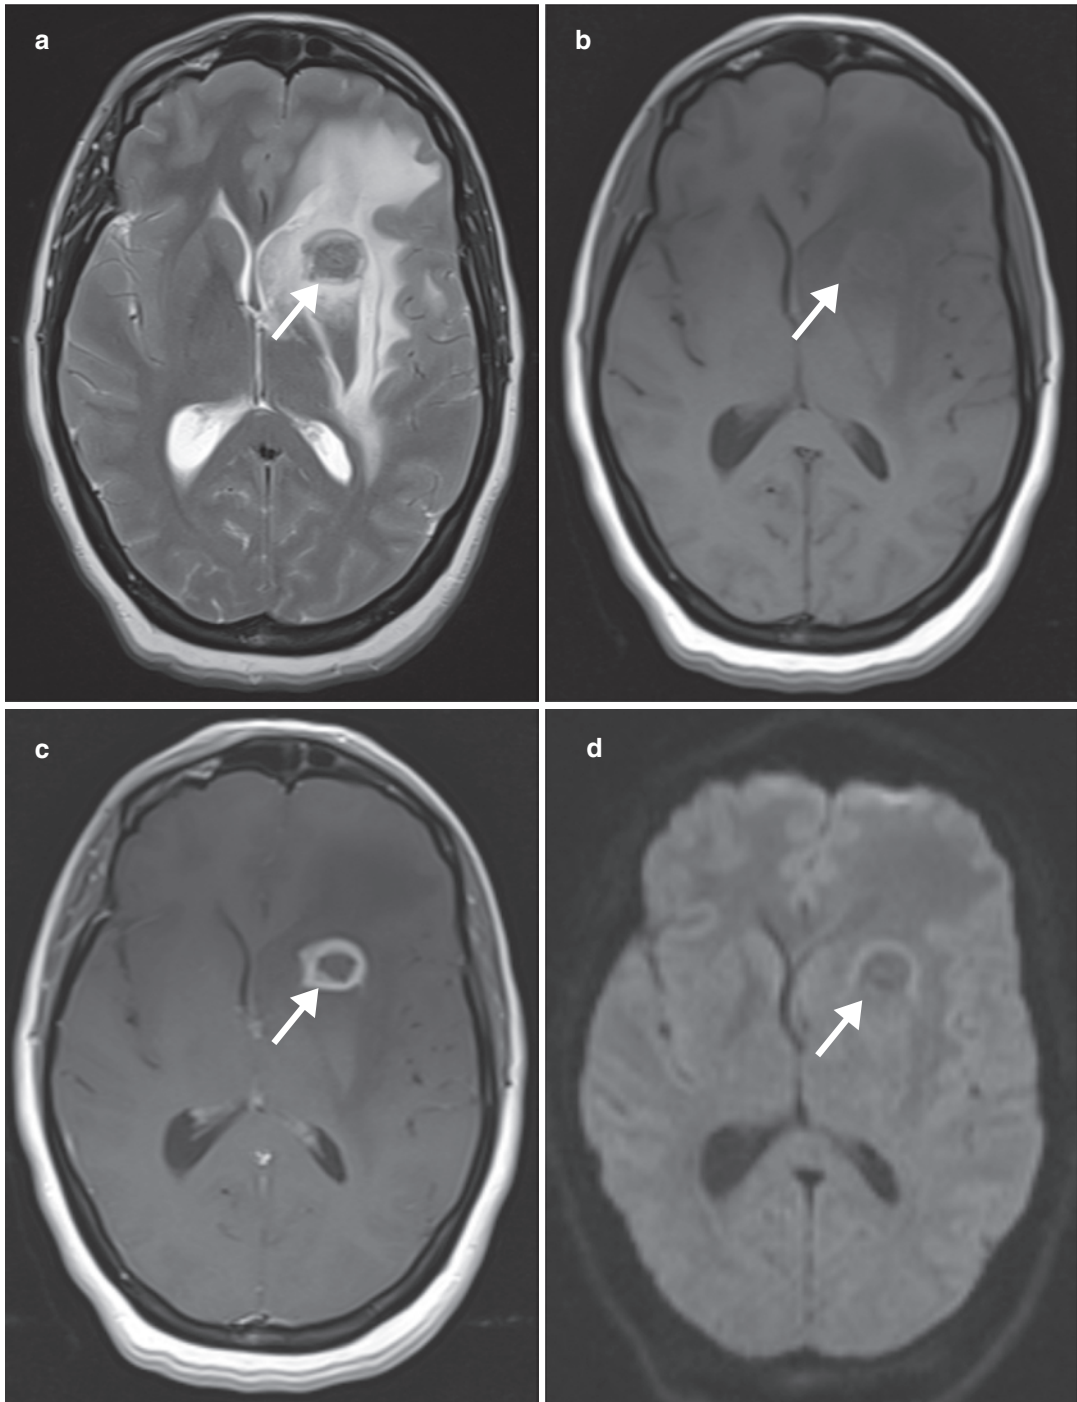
Cerebral parenchymal solid caseating tuberculoma. Axial (a) T2-W, (b) T1-W, (c) contrast-enhanced T1-W, and (d) diffusion-weighted MR images show a left
